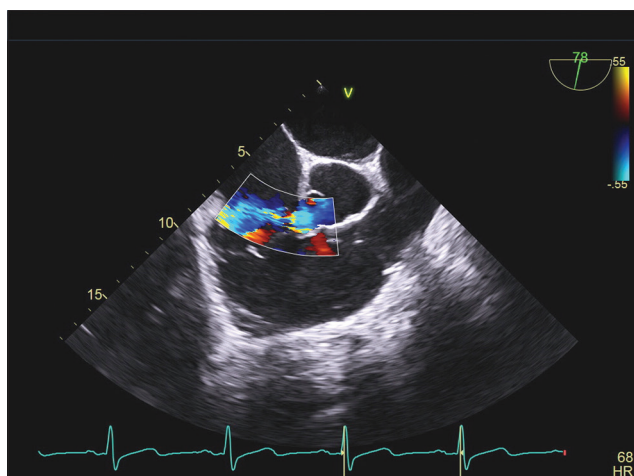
Midesophageal right ventricular inflow-outflow view with color flow Doppler, depicting continuous flow between the right coronary cusp and right atrium
